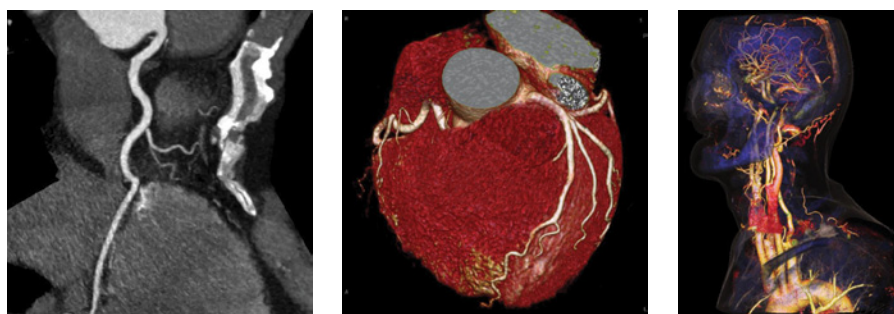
CT images. Left: Coronary CTA, slice thickness 0.6 mm , two-dimensional rendering. Middle: Coronary CTA, slice thickness 0.6 mm , three-dimensional rendering. Right: Carotid artery, slice thickness 0.75 mm , three-dimensional rendering. Courtesy of Siemens AG (collection of MIP, VRT images) and Friedrich-Alexander University Erlangen-Nuremberg, Institute of Medical Physics, Erlangen, Germany. (See insert for color representation of the figure.)
